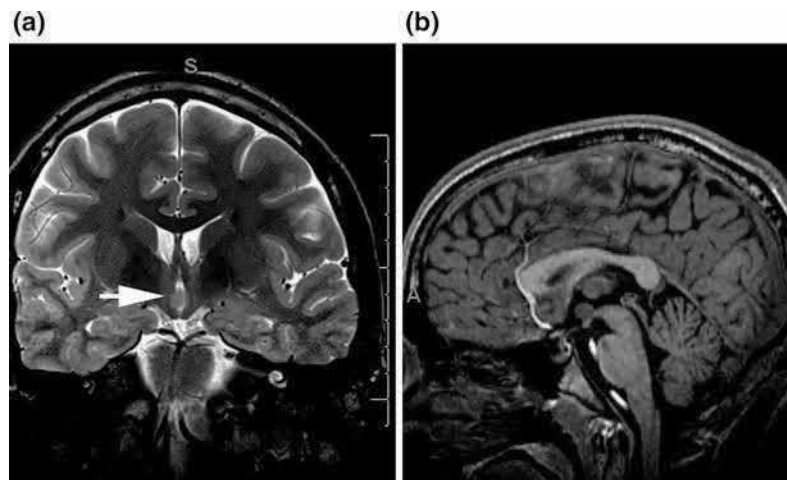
Coronal T2-weighted (a) and sagittal T1-weighted MRI (b) demonstrating ectopic gray matter along the wall of the 3rd ventricle (arrow) in adolescent patient with gelastic seizures. Findings support diagnosis of hypothalamic hamartoma.
